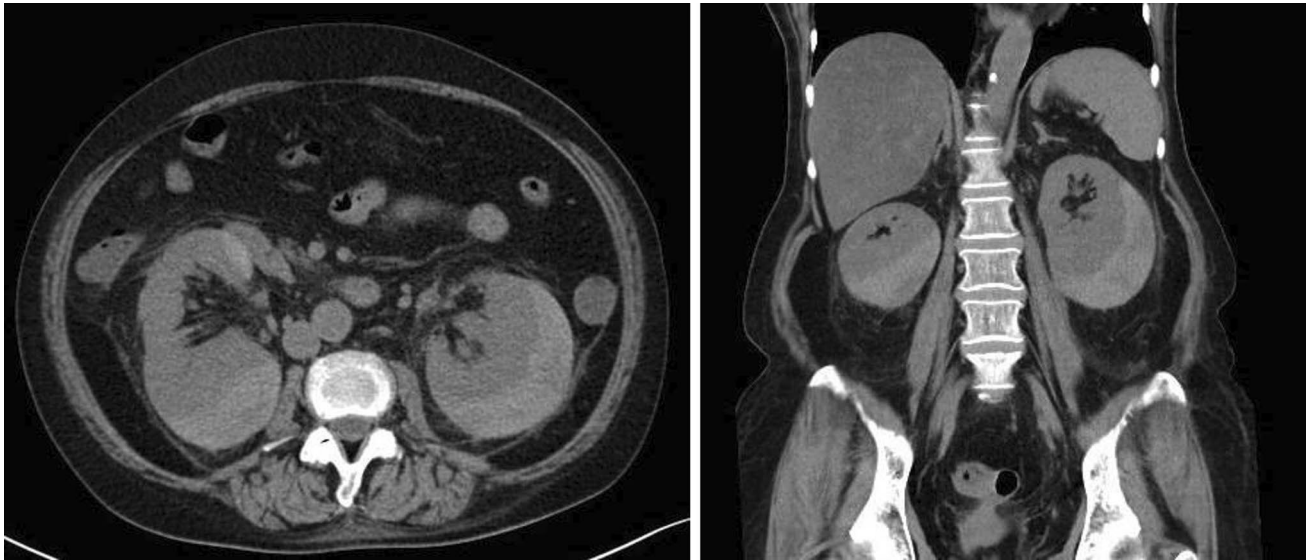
Computed tomography scan showing large bilateral subcapsular renal hematomas
